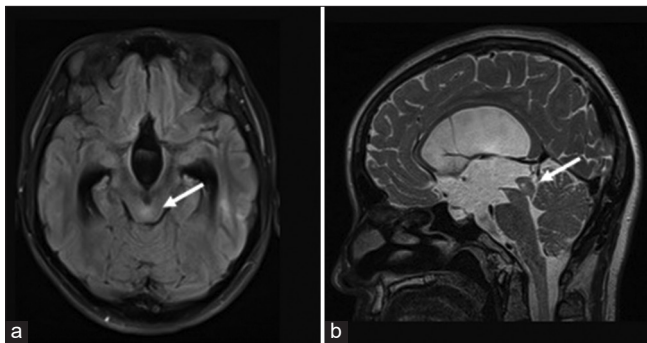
(a) Axial FLAIR MRI showed a hyperintense lesion in the tectal plate (white arrow). (b) Sagittal T2-weighted MRI showed the same lesion with aqueductal stenosis (white arrow head) and ventricular dilation with ballooning of the floor of the third ventricle.
